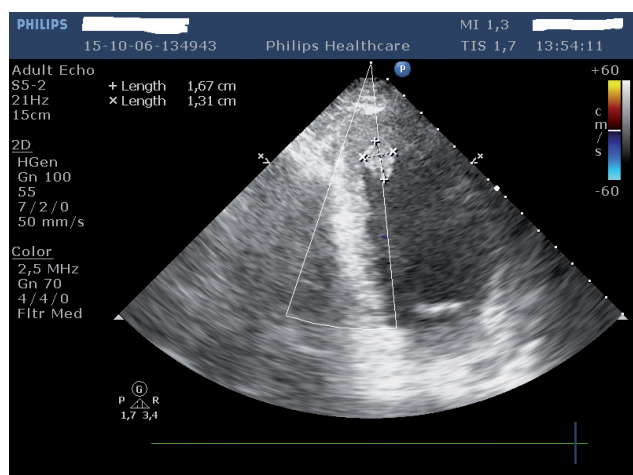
Transthoracic echocardiogram reveals the tumor in the left ventricular cavity attached to the interventricular septum
